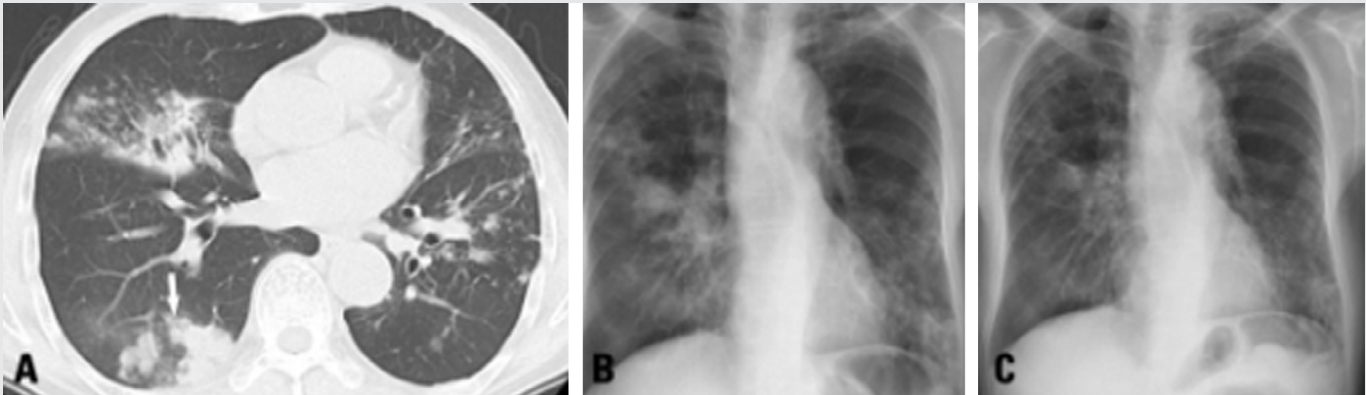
A 72-year-old man with NB-MAC with consolidations treated with anti-MAC therapy. (A) Axial CT shows multifocal cylindrical bronchiectasis and centrilobular nodules with volume loss in both lungs. (B) Plain radiograph obtained on the same day as Figure A shows multifocal consolidations and small nodular opacities in right lung and left lower lung zone. (C) Plain radiography 2 months later shows a decrease in the consolidations and nodules of both lungs.
